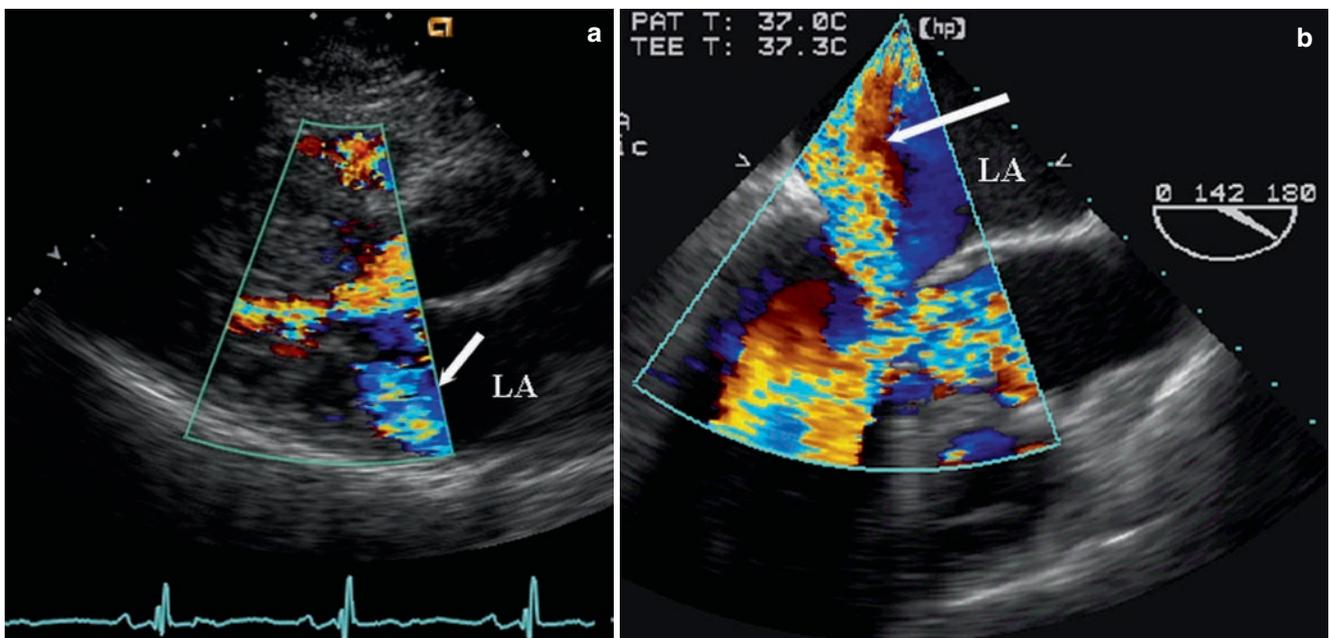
Hypertrophic obstructive cardiomyopathy with severe mitral regurgitation (arrow). (a) Parasternal long-axis view. (b) Trans-oesophageal long-axis view. Note also systolic high-velocity flow (turbulence) in the LV outflow tract
